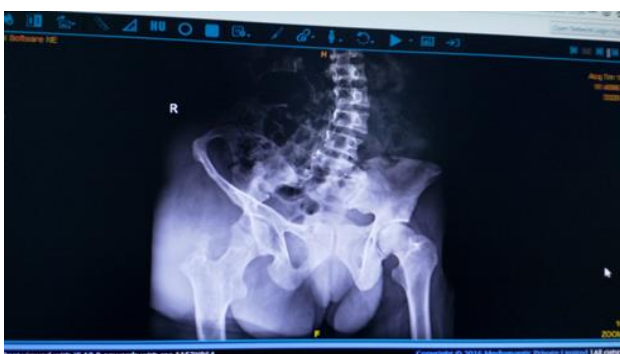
X-ray pelvis showing scoliosis with right iliac bone loss
